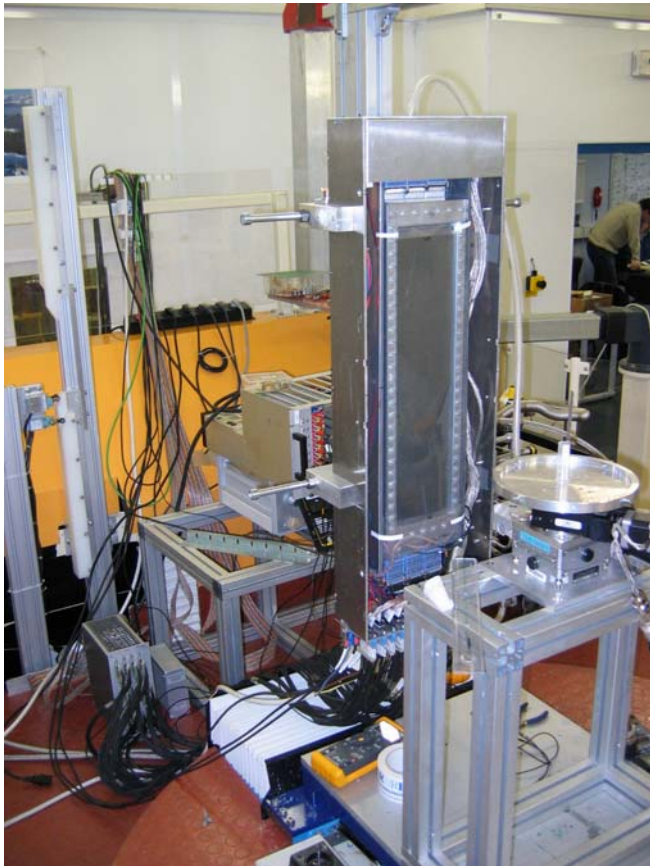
X-ray area detector
